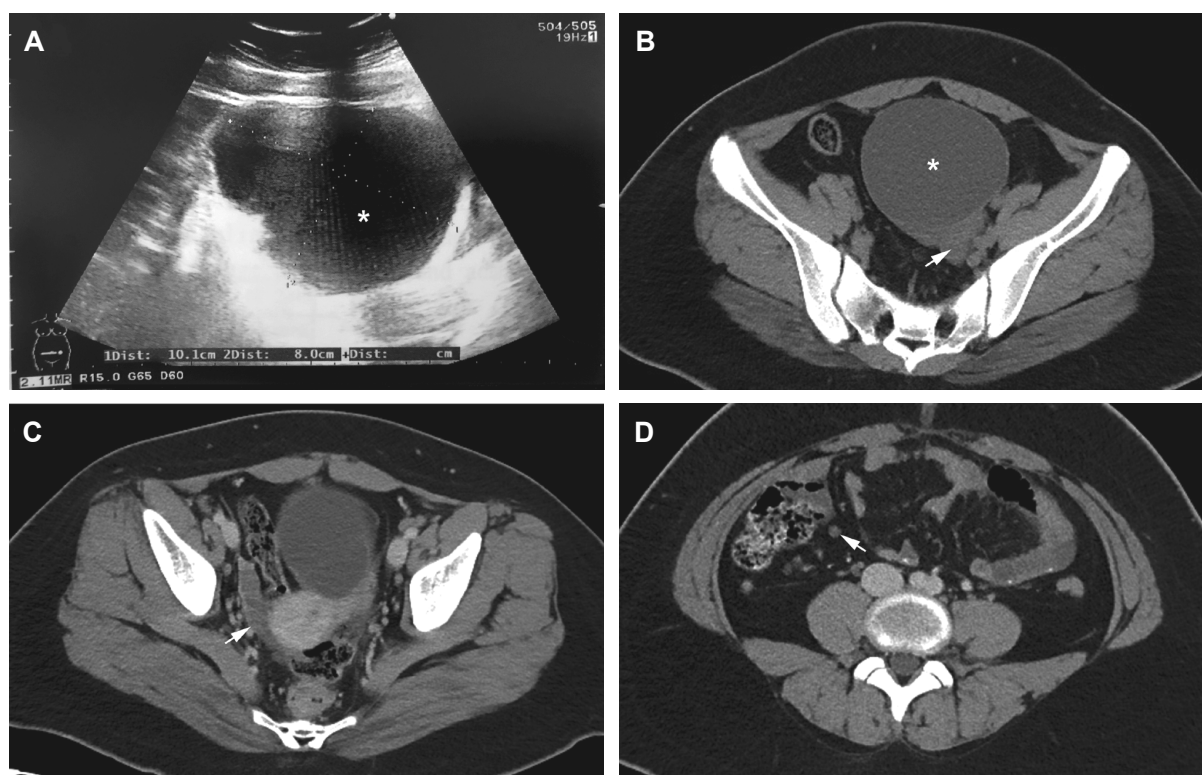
(A) Abdominal ultrasound revealing a hypodense and homogenous left ovarian cystic lesion of size 10 cm × 9 cm without apparent septum. Abdominal and pelvic computed tomography showing (B) a cystic lesion of size 9.3 cm in the left parametrial region (asterisk) with (C) ascites (arrow) and (D) mesenteric lymph node enlargement (arrow), highly suggestive of pelvic extension of ovarian cancer.
